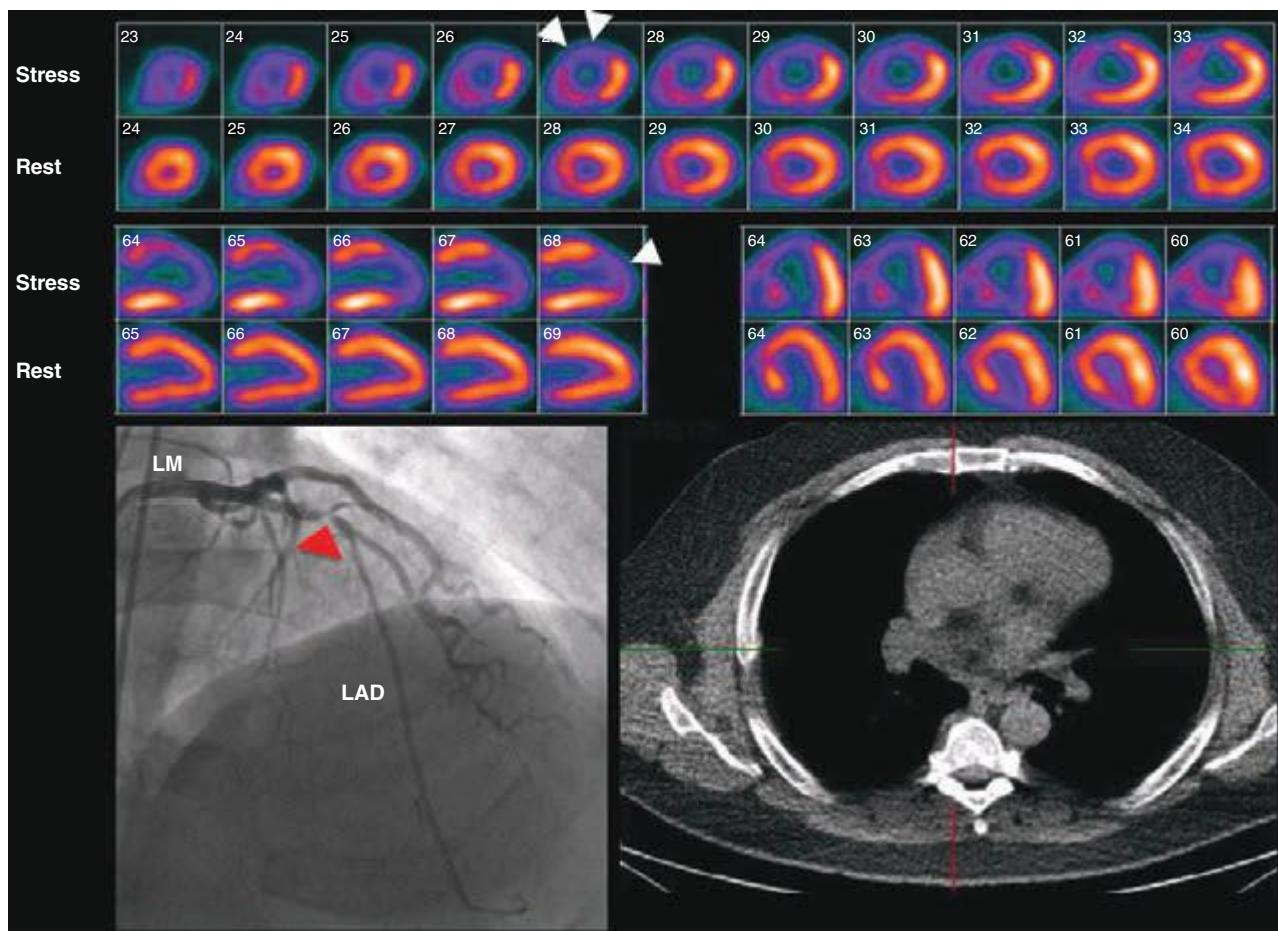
12 Stress and rest rubidium-82 myocardial perfusion positron emission tomography images (top), noncontrast gated computed tomography images (lower right), and selected coronary angiographic images obtained on a 59-year-old male patient with atypical angina. Despite the absence of significant coronary calcifications (Agatston calcium score = 0), the perfusion images demonstrated a dense and reversible perfusion defect involving the anterior and anteroseptal walls (arrows), reflecting significant obstructive disease in the left anterior descending coronary artery (LAD), confirmed on angiography. LM, left main artery.
